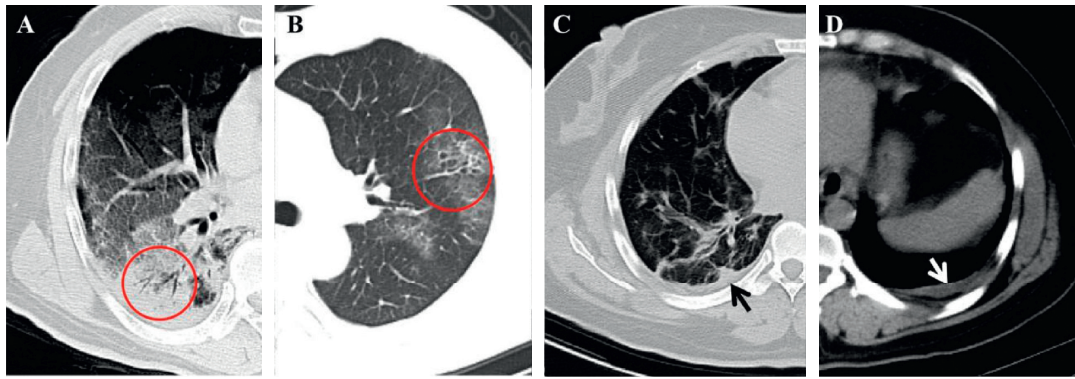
(a) A 60-year-old male COVID-19 patient with initial symptoms of dry cough and fever for 3 days. CT scan shows air bronchogram in the right lower lobe (red circle) (10 days after the onset of initial symptoms). (b) A 46-year-old male COVID-19 patient with fever. CT scan demonstrates bronchiolectasis in the left upper lobe (red circle) (14 days after the onset of initial symptoms), and the bronchial wall thickening is also observed. (c, d) A 40-year-old female confirmed patient with nasal discharge and generalized aches for 11 days. The CT shows the pleural thickening (black arrow) and a small amount of pleural effusion (white arrow) (12 days after the onset of initial symptoms).
